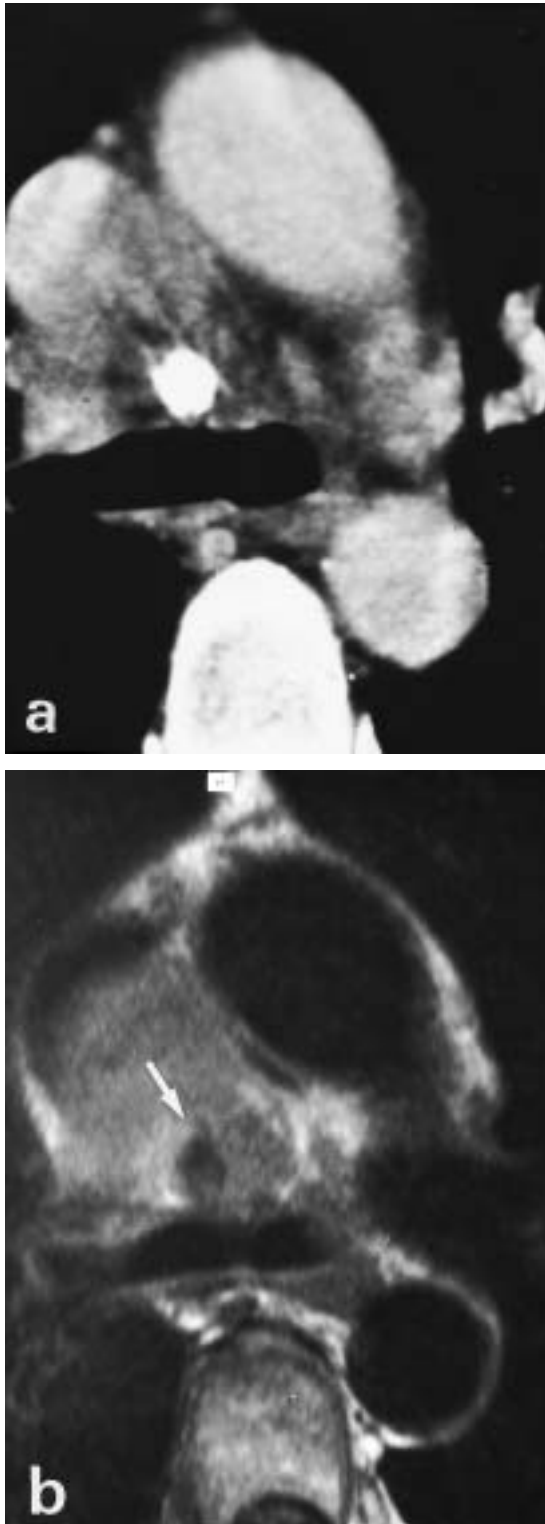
Calcified mediastinal lymph node. a) computed tomography shows large calcification in a pericardial lymph node in a patient with multiple mediastinal and hilar metastases due to breast carcinoma. b) Corresponding transverse T1-weighted magnetic resonance image allows only suggestion of calcification due to signal-void in this region (arrow).
